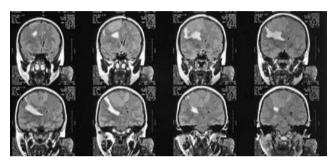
MRI showed intracranial mixintensity mass which enhanced homogenously with contrast administration at the bilateral parasagittal with some peritumoral oedema attached to cerebral falx.
